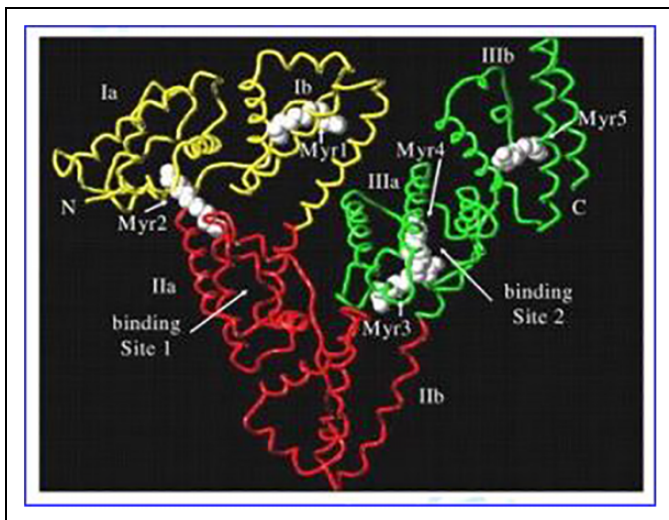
X-ray structure of human serum albumin.⁸⁵
